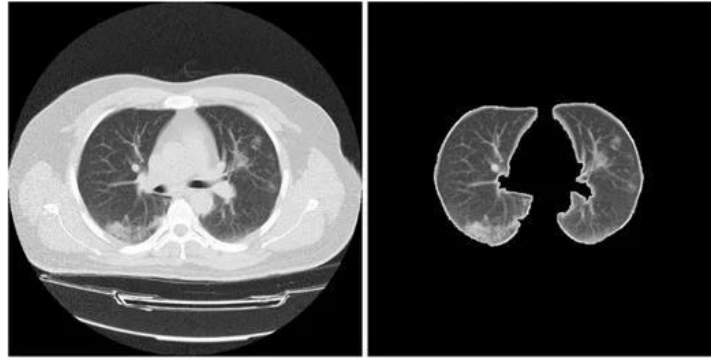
Lung boundary identification samples: *a* — Original CT image; *b* — Preprocessed CT image
